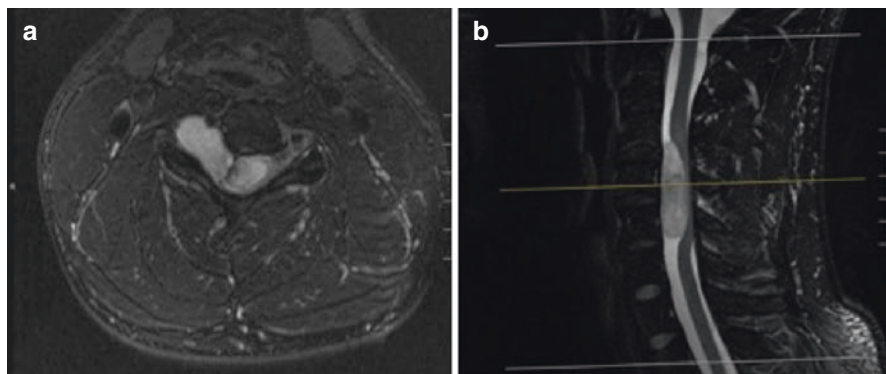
T2 axial (a) and T2 sagittal (b) MRI images of a 27-year-old man with a dumbbell type schwannoma that extended through the C4–5 foramen. The tumor is amenable to a surgery utilizing a posterolateral approach and posterior facetectomy
